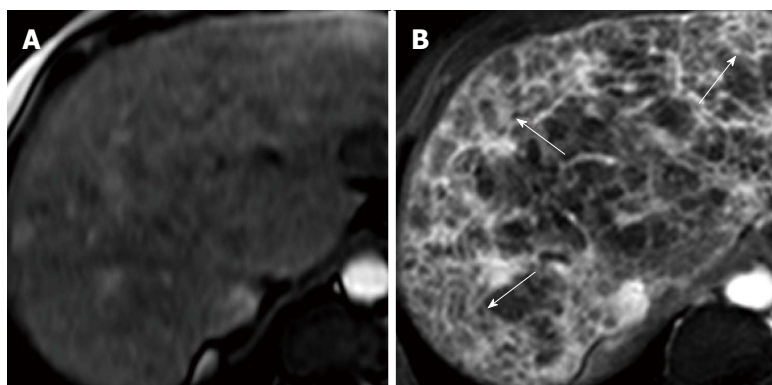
Transverse MR images of cirrhotic liver *in vivo*^[128]. A: SPIO-enhanced two-dimensional spoiled gradient echo (SPGR) image with echotime of 2.65 ms; B: Double-enhanced SPGR image at the same level, showing hyperintense reticulations and hypointense nodules (arrows), thought to represent fibrous septal bands surrounding regenerative nodules.
